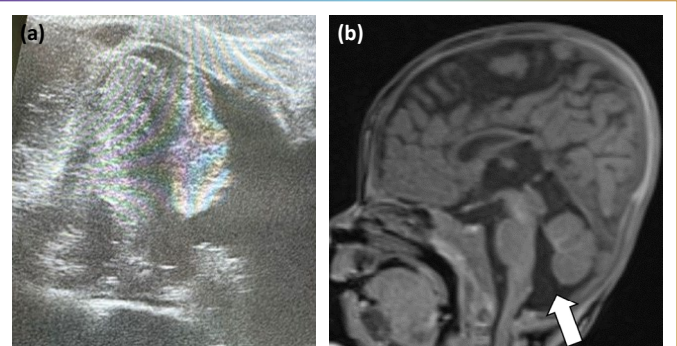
MF-CUS examination of a 32-week-old newborn shows a small gap inferior to the vermis and between the cerebellar hemispheres (a). Sagittal magnetic resonance image in the same patient demonstrating a small gap inferior to the vermis (arrow) identified as 'inferior vermian hypoplasia' (b).
